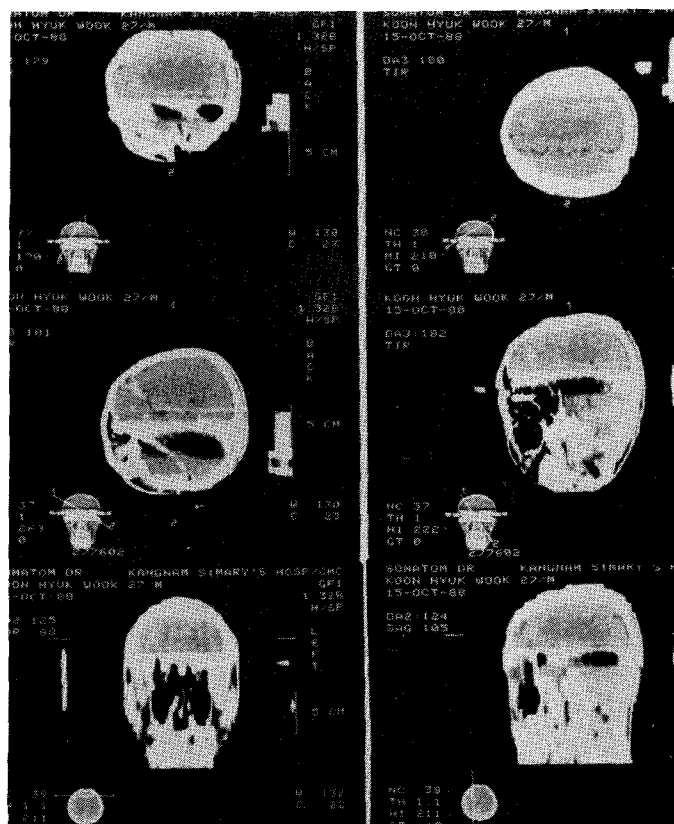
The profile of the head along the preset planes of irradiation reconstructed from CT data.
